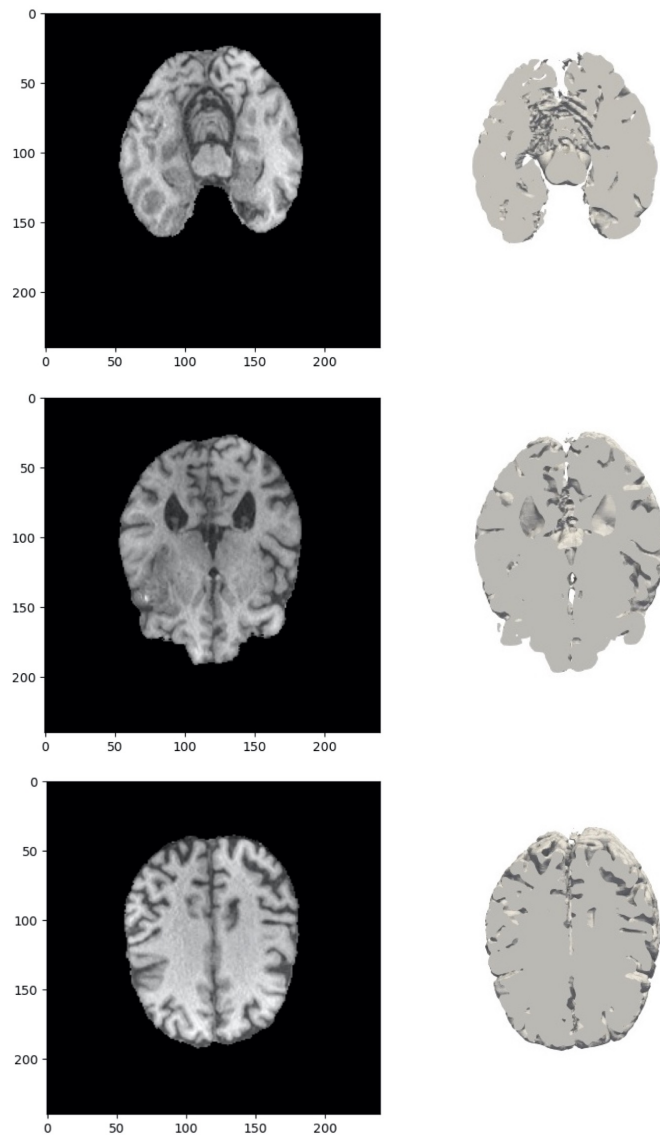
Real Brain MR image data (left) reconstructed Brain in 2D (right)
